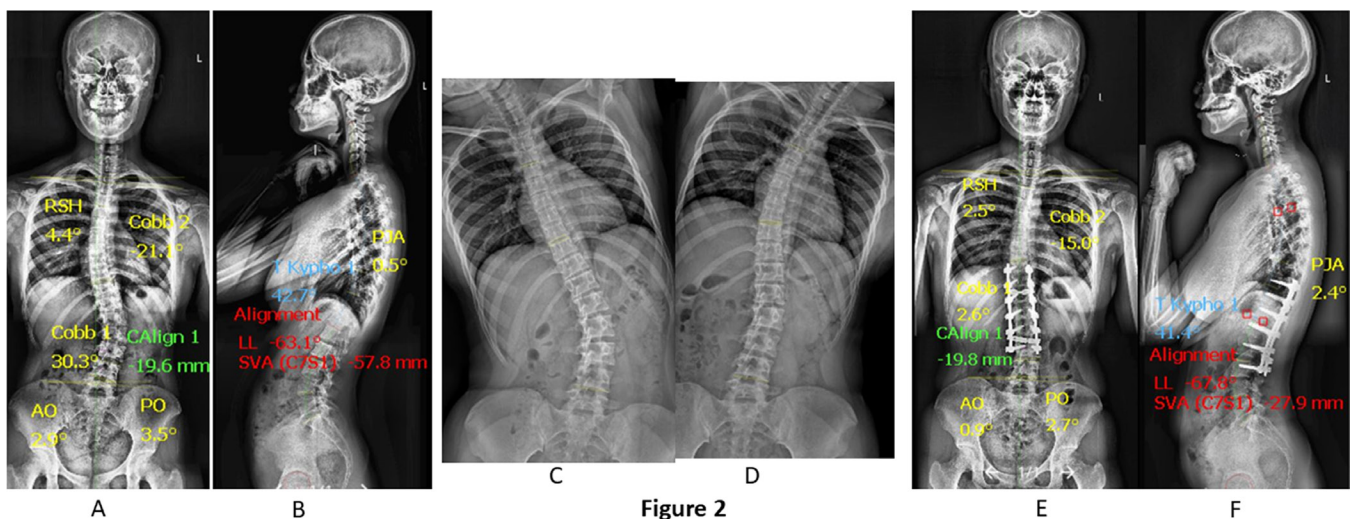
A 16-year-old girl with adolescent idiopathic scoliosis Lenke 5 curve. (A and B) Preoperative posteroanterior and lateral standing radiograph. (C and D) Preoperative bending radiography. (E and F) Three years postoperative posteroanterior and lateral radiograph. She was treated with posterior en-bloc direct vertebral rotation (DVR) with upper instrumented vertebra (UIV) = upper-end vertebra (UEV).
